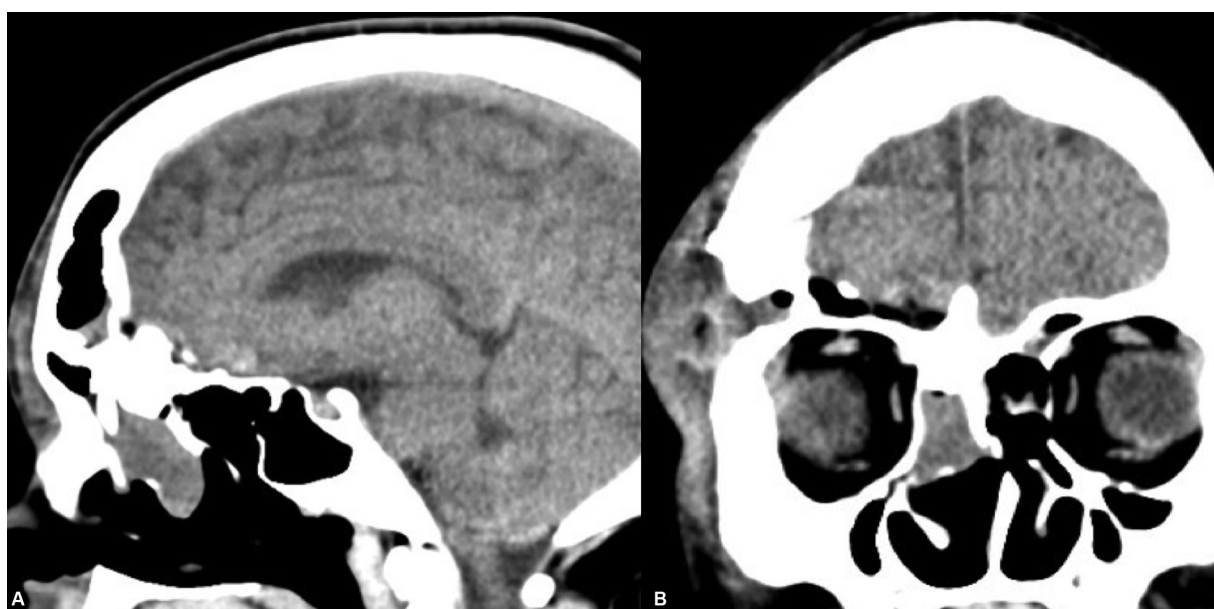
A and B - Postoperative head computed tomography in sagittal and coronal sequences showing a complete correction of anterior fossa floor with bone cement and cerebrospinal fluid leak resolution.
